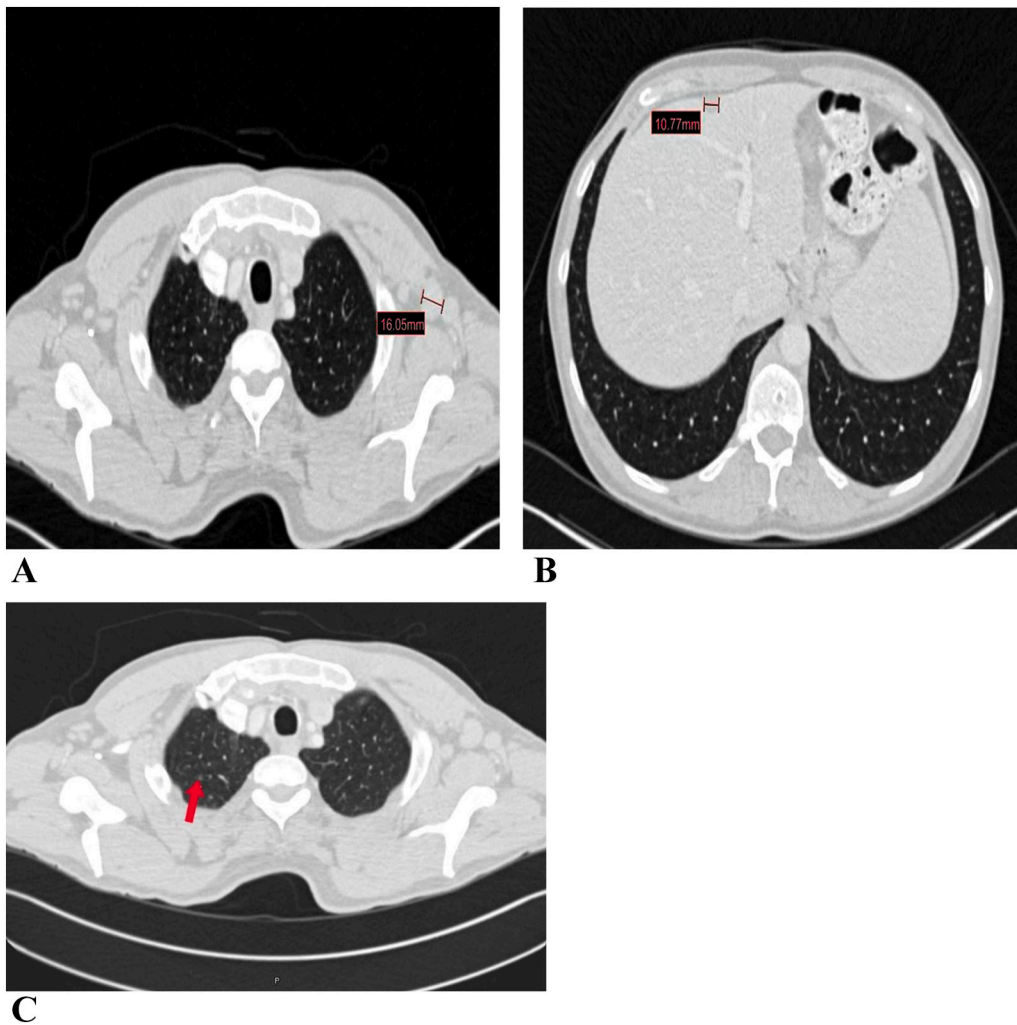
Whole body CT (axial) with oral and IV contrast showing: A) supra-diaphragmatic lymphadenopathy; B) infra-diaphragmatic lymphadenopathy; and, C) few small subsolid pulmonary nodules.
